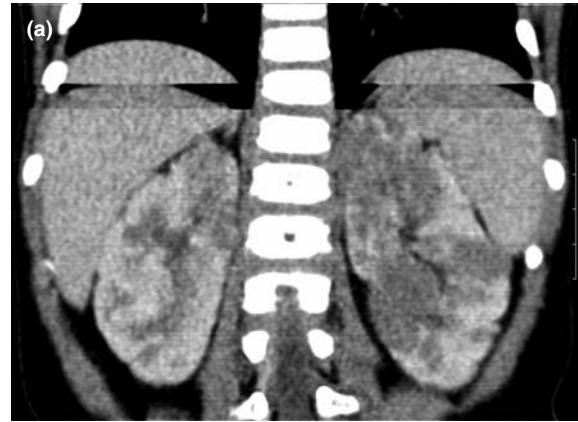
Nephroblastomatosis. (a) CT with intravenous contrast reconstructed in the coronal plane showing extensive nephroblastomatosis in both kidneys (the misregistration at the level of the diaphragm is due to the patient taking a breath during the scan). (b) MRI in the same patient demonstrates the same finding (in the transverse plane) but without the need for ionising radiation.
